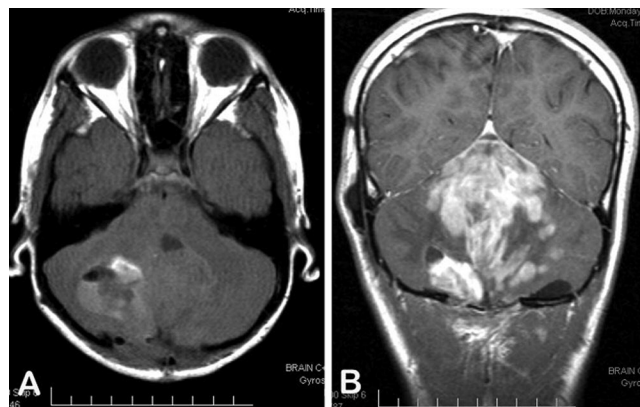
A: Axial T1-weighted contrast-enhanced MR image obtained at the 5-year follow-up showing a residual cerebellar mass measuring approximately 6 cm in diameter with cystic areas and an enhancing nodule. B: An MR image obtained at the 7-year follow-up revealing a rapidly enhancing mass involving the whole of the cerebellar vermis and paramedian cerebellar hemispheres. The mass measures  $8 \times 7 \times 6.7$  cm.
